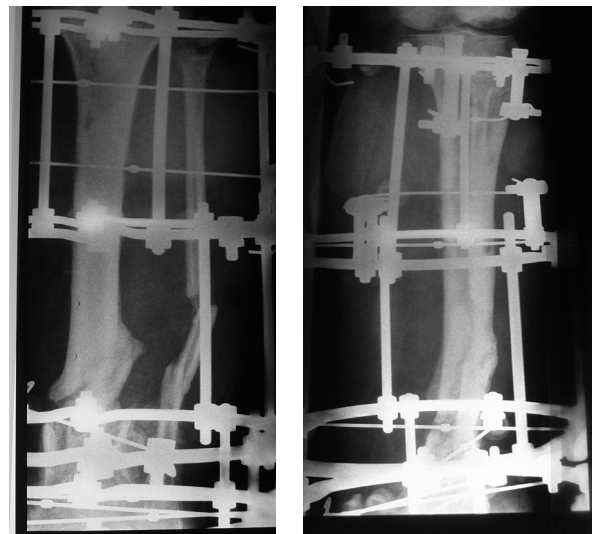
On the X-ray recordings of the right lower leg and ankle made in the AP and LL projections, the broken right lower leg in the healing phase stabilized with external skeletal fixation can be seen
